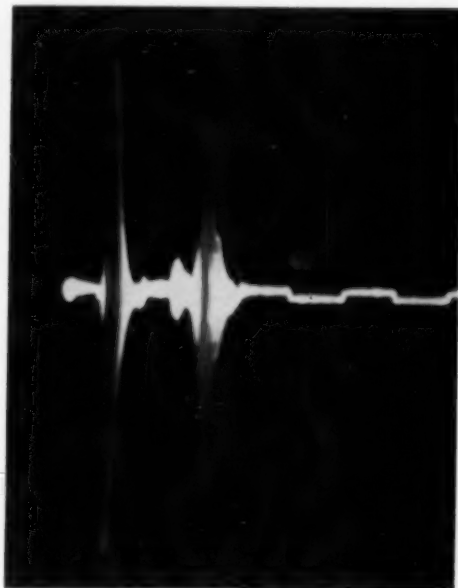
(Mundt and Hughes). Ultrasonic tracing of another child's eye containing a retinoblastoma.
